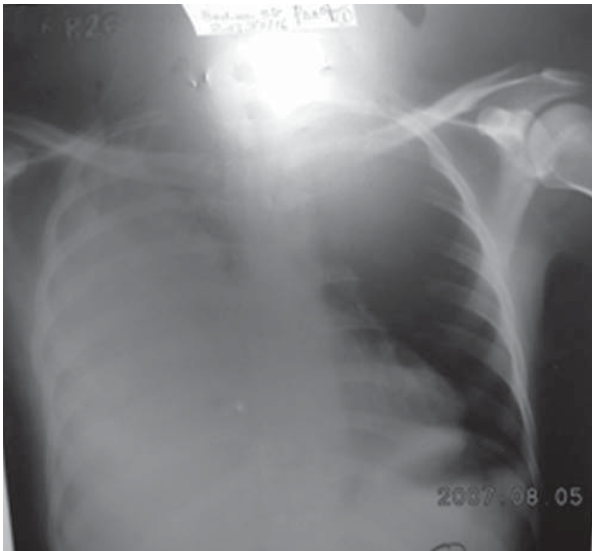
Pre operative X-ray, Chest:
